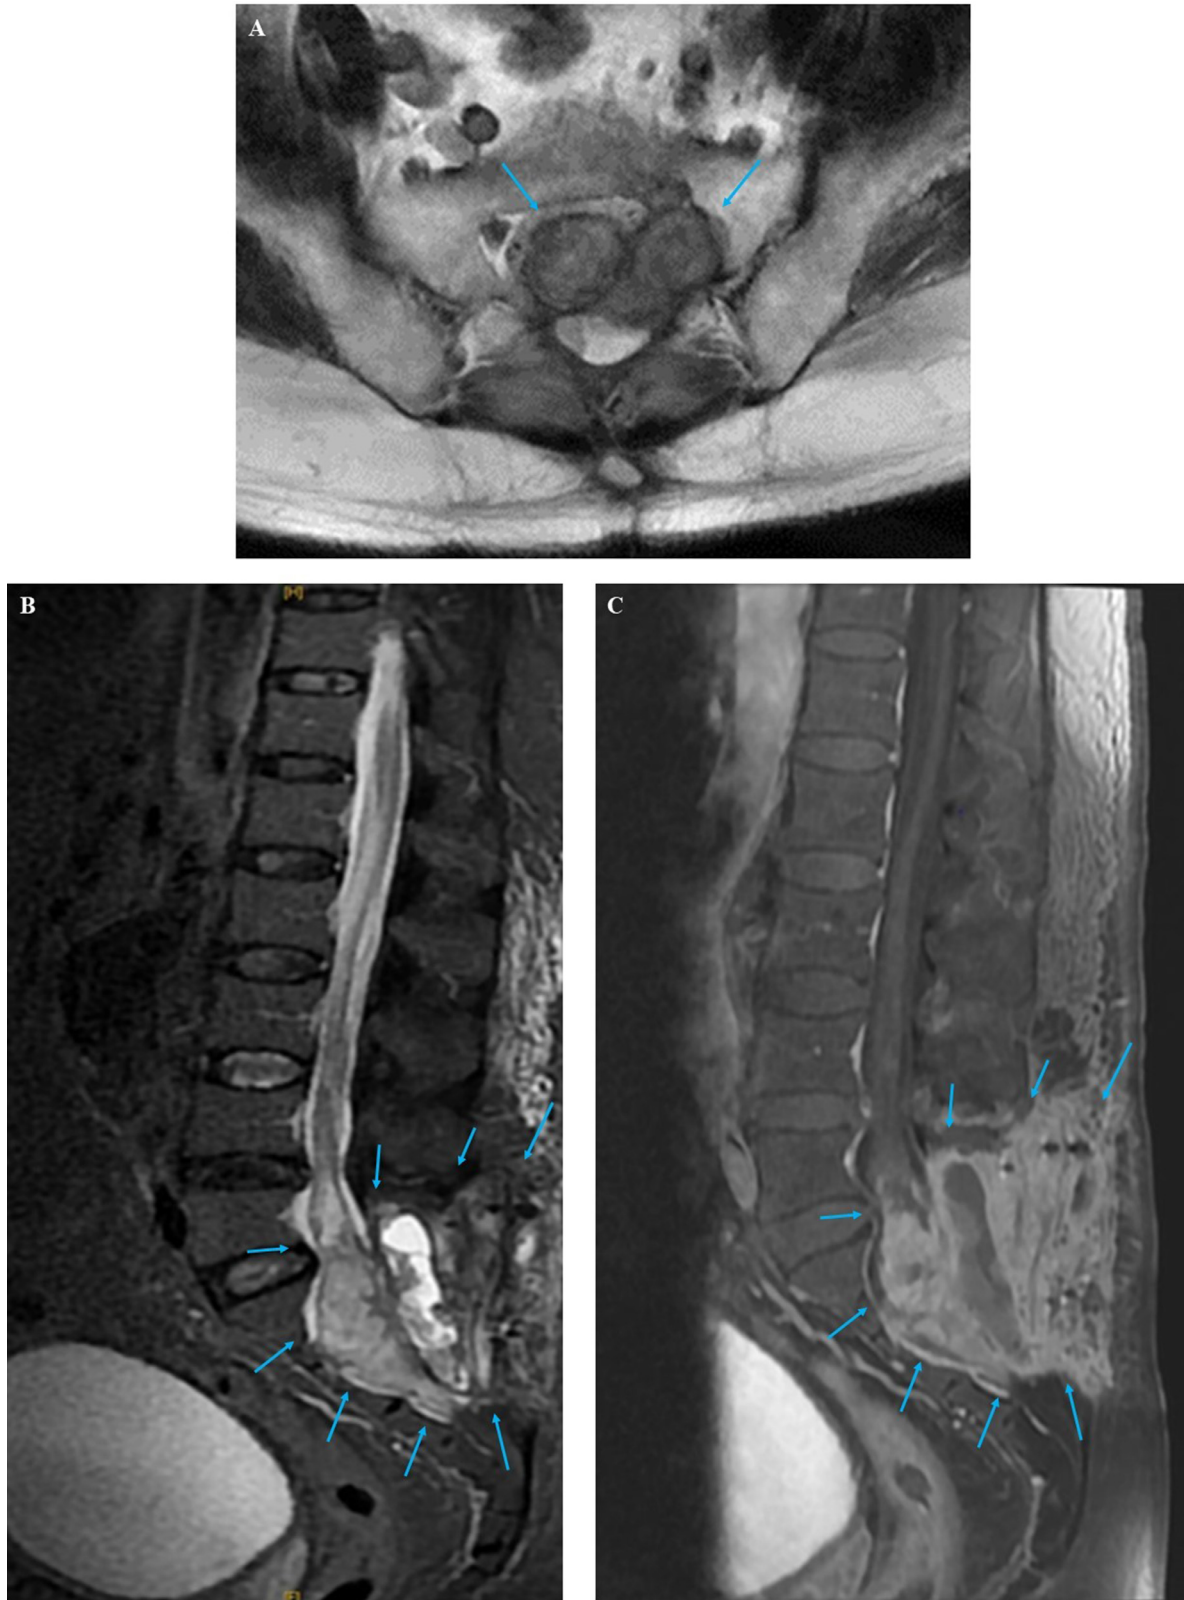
Magnetic Resonance Images showing a heterogeneous expansile endocanal mass in the terminal lumbosacral region with hyperintense cystic component and isointense patches on axial T2-weighted sequence (A), sagittal T2-STIR sequence (B) and intense heterogeneous enhancement on sagittal postcontrast T1-weighted image (C) [blue arrows], associated to areas of bone destruction and locoregional infiltration.
